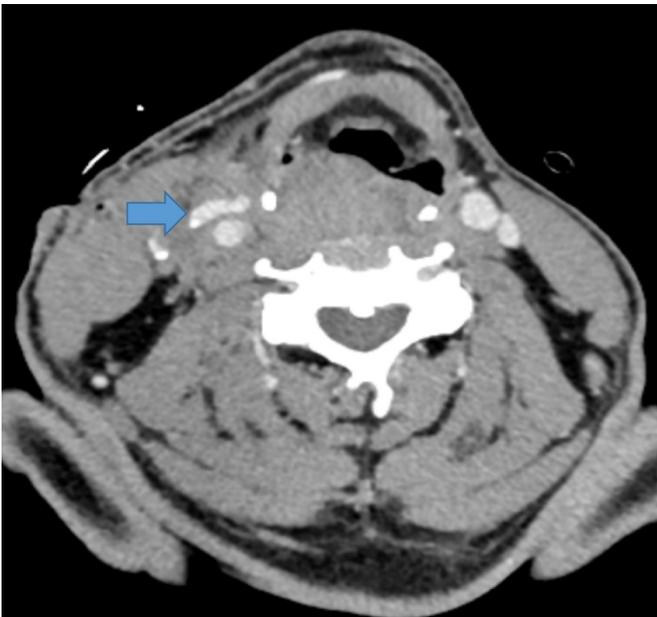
Delayed images of the neck 60 s after the initial scan CTA shows a change in the morphology of the pseudoaneurysm (arrow), in keeping with active extravasation.
